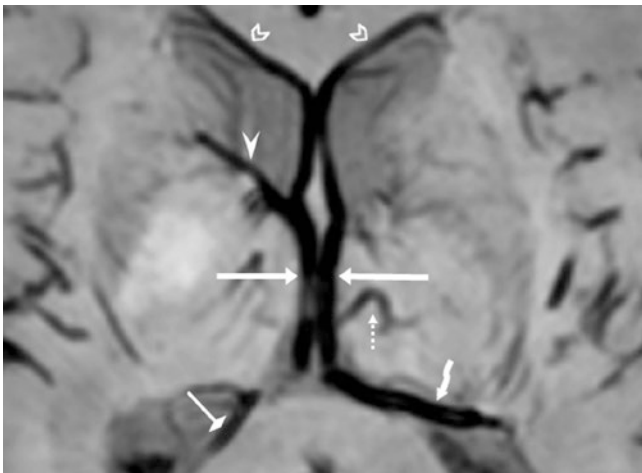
90-year-old with weakness (negative MRI). 3 T 12 mm thickness SWI shows an asymmetric left DLV (*curved arrow*), a right MAV (*diamond-tip arrow*), a right ACV (*arrowhead*), and a left superior thalamic vein (STV) (*thin dotted arrow*). Also seen are the ASVs (*chevrons*) and ICVs (*long arrows*)
